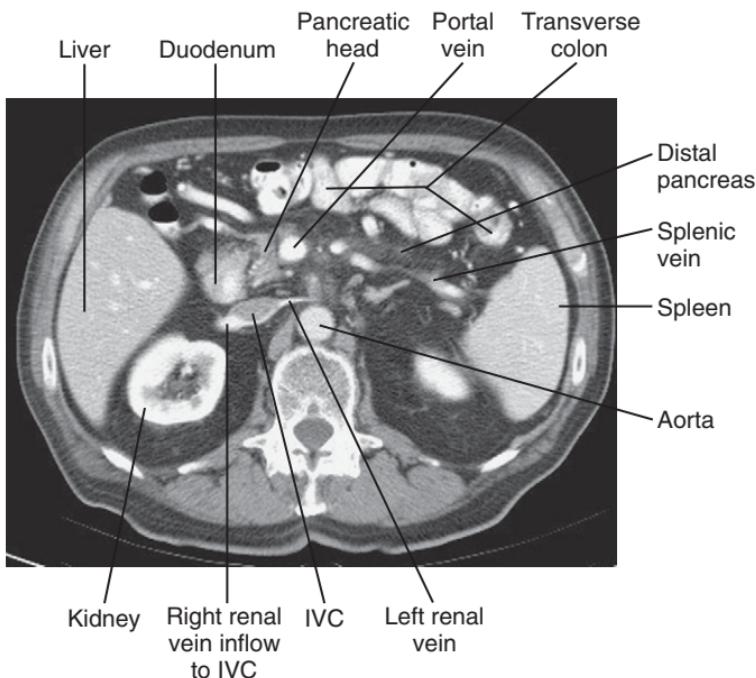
Normal CT focusing on upper abdomen.
